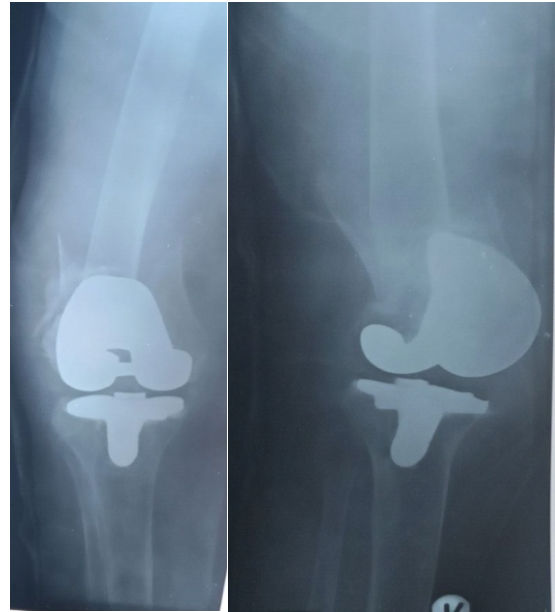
Anterior- posterior and Lat x-ray views of the right knee showing the peri- prosthetic fracture
